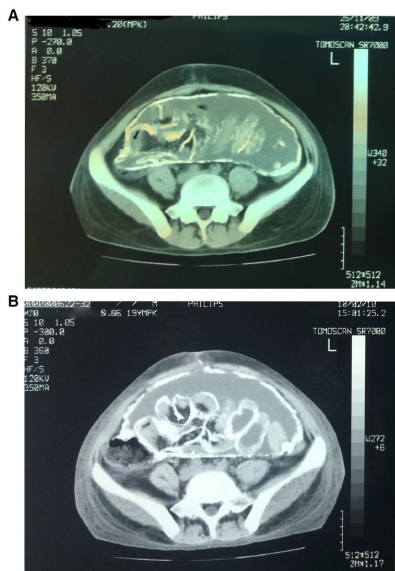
a Abdominal CT scan (Nov 2009) showing excessive peritoneal thickening, multiple intra-abdominal adhesions of bowel loops and a calcified fibrous cocoon wrapped around the bowel; b abdominal CT scan (Feb 2010) showing persistence of calcified intra-abdominal lesions and peritoneal thickening
